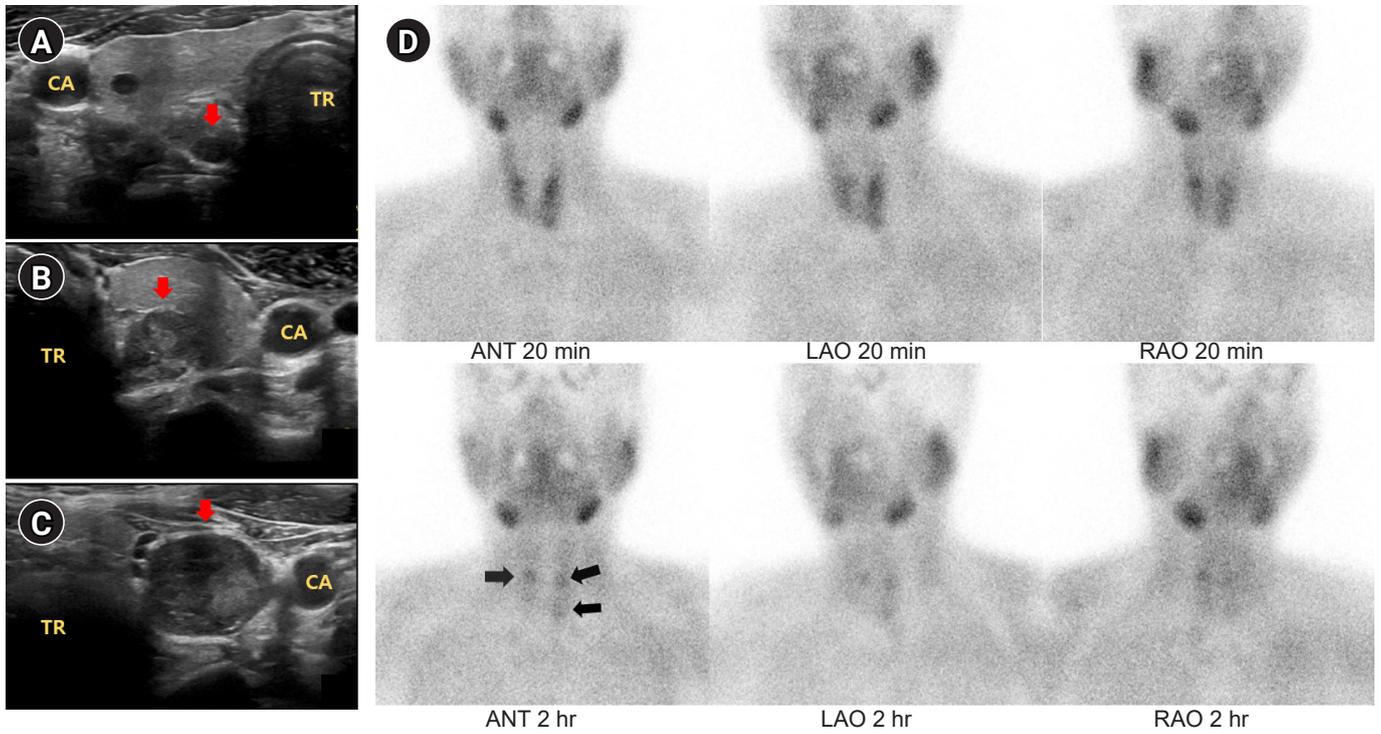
Ultrasonography and ^{99m}Tc sestamibi single photon emission computed tomography (SPECT) of parathyroid glands (arrow). (A) Right superior parathyroid gland. (B) Left superior parathyroid gland. (C) Left inferior parathyroid gland. (D) Parathyroid SPECT images acquired 20 minutes and 2 hours after the intravenous ^{99m}Tc sestamibi injection. CA, carotid artery; TR, trachea, ANT, anterior; LAO, left anterior oblique; RAO, right anterior oblique.
